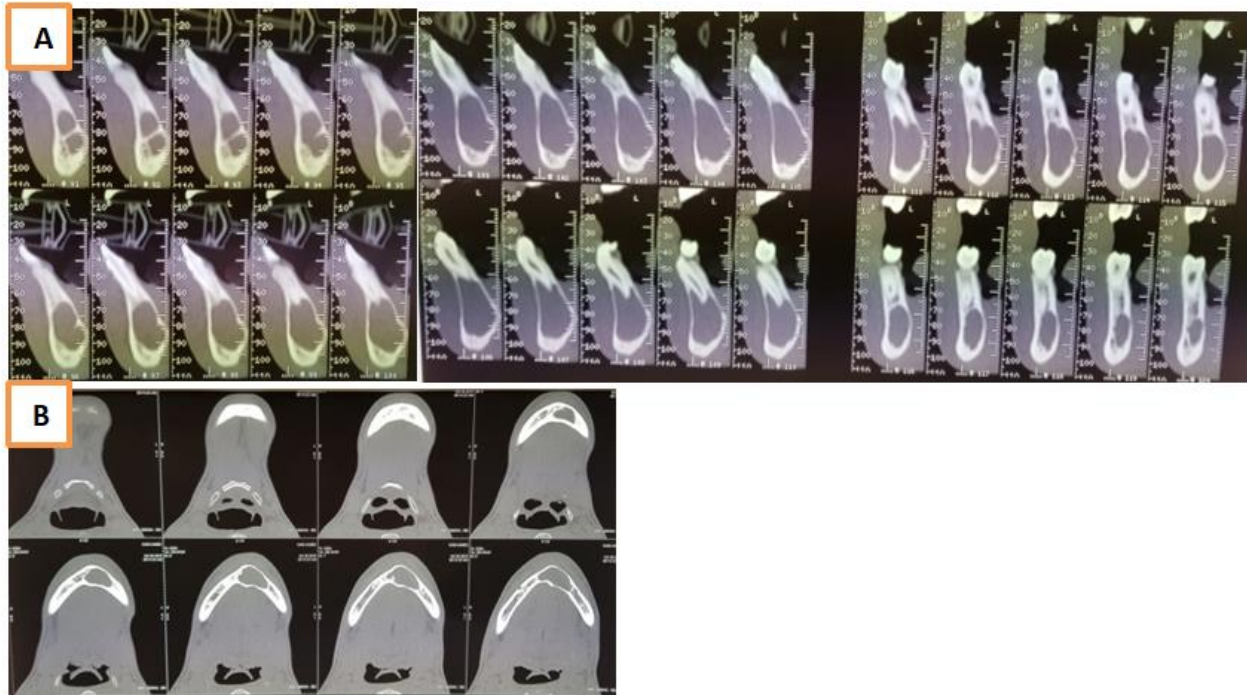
Patient 3 mandibular CT scan. A: Oblique coronal sections. B: Axial sections Well limited radiolucency located in the symphyseal region. Absence of cortical deformation
